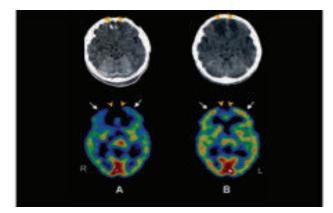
CT (top) and 99mTc-HMPAO SPECT (bottom) images from 16-y-old patient with traumatic brain injury after traffic accident. (A) CT at time of admission shows subarachnoid hemorrhage with small contusional hemorrhagic foci in both frontal lobes (orange arrowheads). SPECT was subsequently performed and shows absence of tracer uptake (cold areas) in anteromedial aspect of both frontal lobes corresponding to hemorrhagic lesions, in addition to global hypoperfusion, more marked in both frontal cortices (white arrows). (B) CT and SPECT images obtained 1 mo later at time of discharge after clinical recovery. Hypodense images in both frontal lobes can be seen on CT as consequence of hematoma's resolution. Corresponding cold areas persist on SPECT image (orange arrowheads) but show improvement in global cerebral perfusion, particularly in both frontal lobes (white arrows). Source: Ana M. Catafau "Brain SPECT in Clinical Practice. Part I: Perfusion" J Nucl Med 2001; 42:259-271
